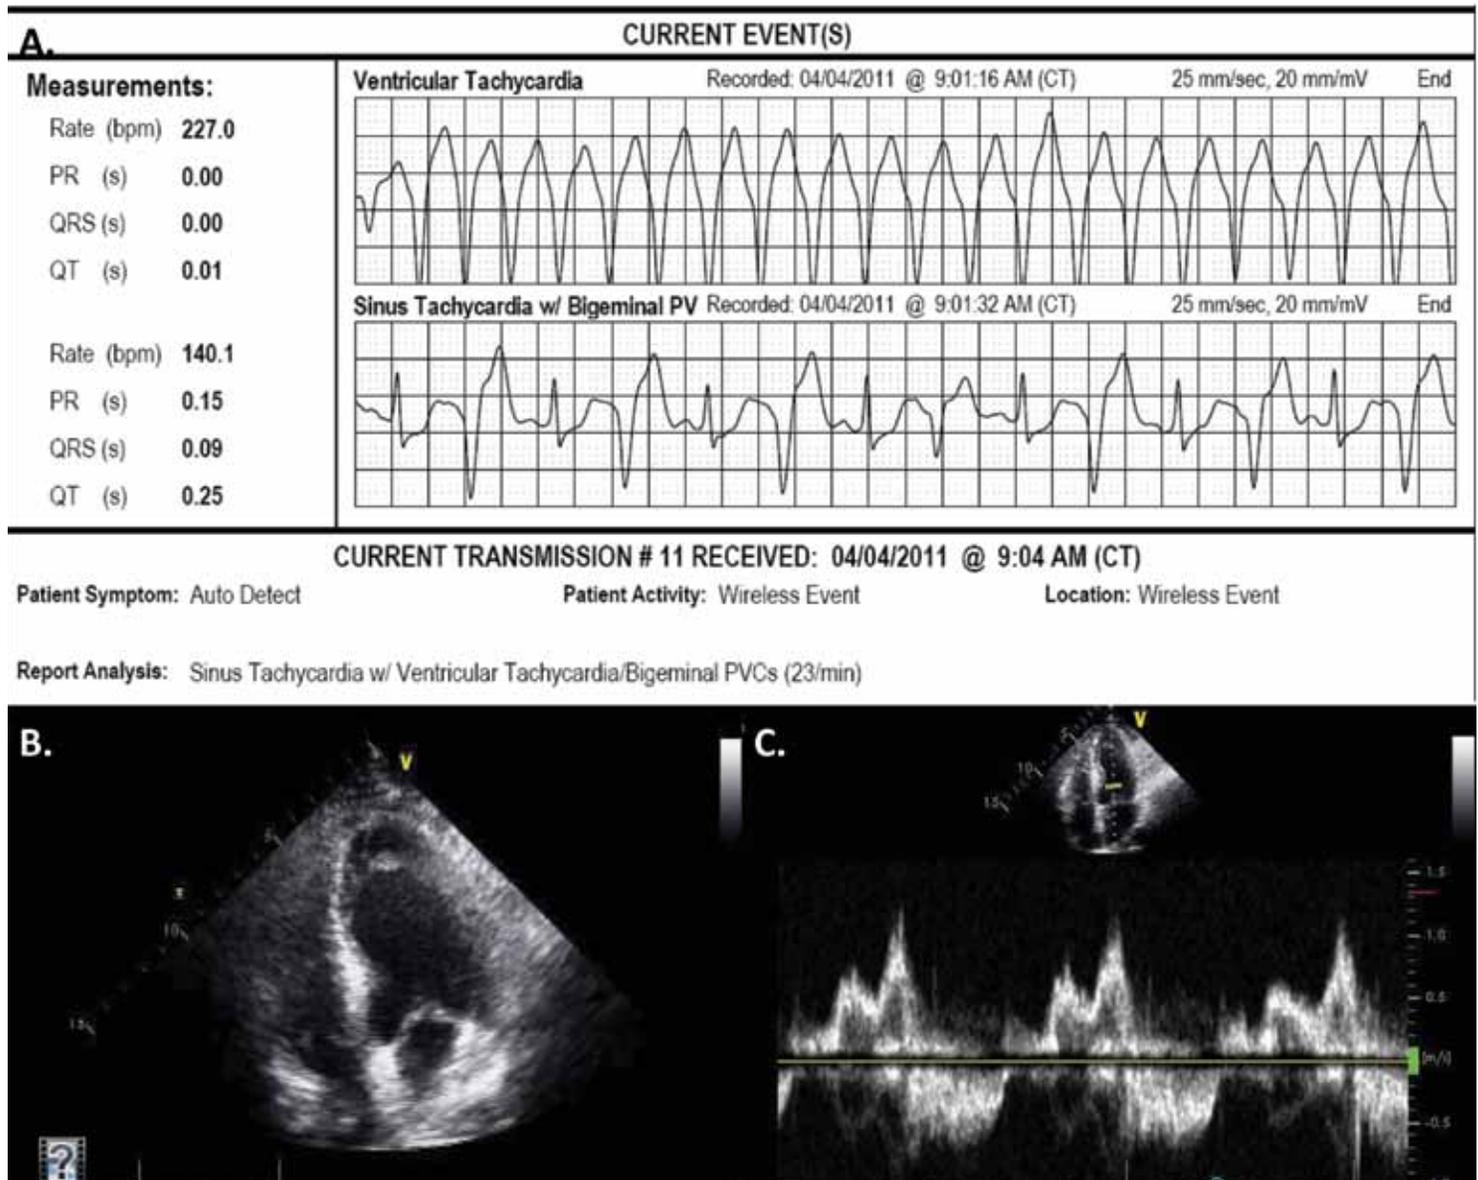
Ventricular tachycardia in a patient with AL cardiac amyloidosis. Example of a 70-year-old patient with palpitations from ventricular tachycardia due to AL amyloidosis, which was detected by endomyocardial biopsy. An AICD was implanted for primary prevention of sudden cardiac death with appropriate AICD shock 2 months later (aborted cardiac arrest) and restoration of sinus rhythm. Of note, the patient had no evidence of significant left ventricular hypertrophy or biatrial enlargement (panel B) and he had normal estimated LV filling pressure by echocardiography (panel C). AICD: implantable cardioverter defibrillator; LV: left ventricular.
